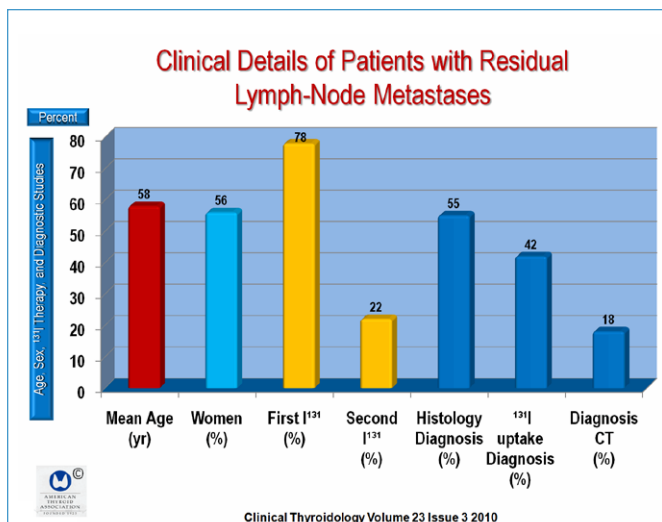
This figure shows the clinical details of patients with residual lymph-node metastases treated with adjuvant ¹³¹I therapy. The most sensitive imaging studies in this setting is FDG CT/PET scans.
